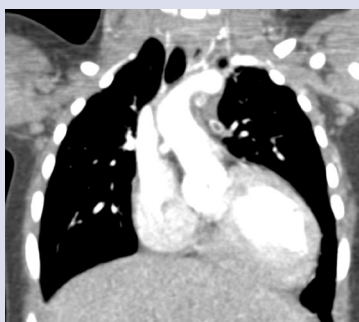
Computed tomography scan of described patient with pulmonary atresia and ventricular septal defect
